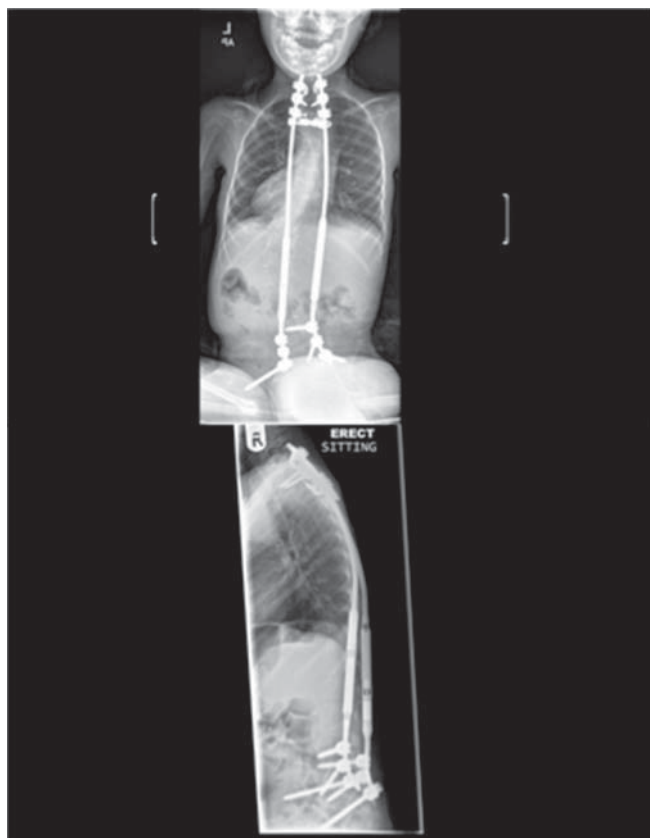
AP and lateral radiographs after second distraction—6 months. AP indicates anteroposterior.
